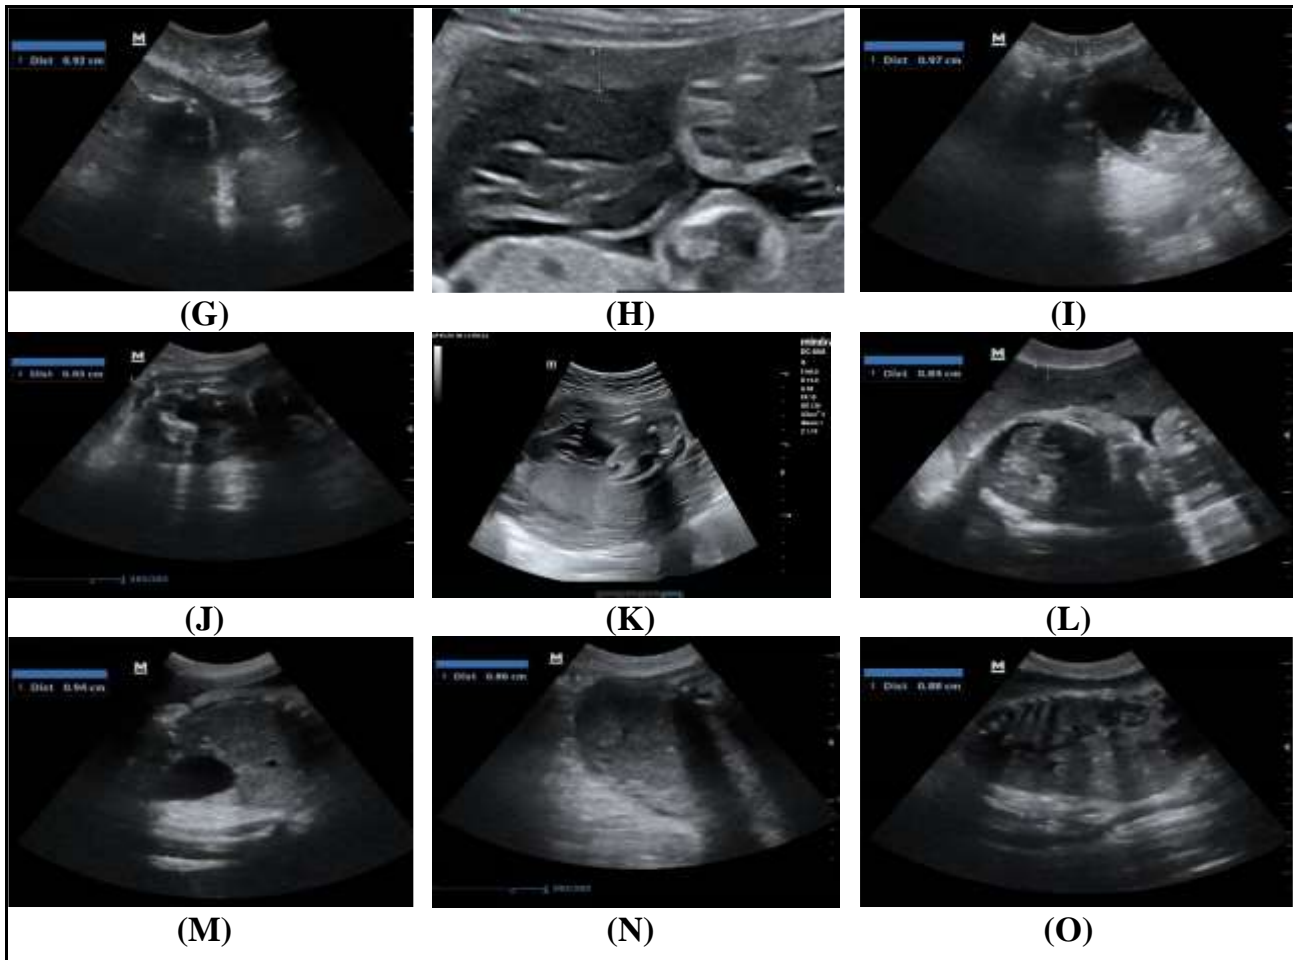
Ultrasound showing the measurement of anterior MT (A) Group A1, (B) Group B1 with gestational age 28 weeks, (G) Group B2, (H) Group A2 with gestational age 30 weeks, (K) Group A3, (L) Group B 3 with gestational age 32 weeks, fundal MT (C) Group B1, (D) Group A1 with gestational age 28 weeks, (I) Group B2, (J) Group A2 with gestational age 30 weeks, (M) Group A3, (N) Group B3 with gestational age 32 weeks, (E) MT at anterior, (F) MT at fundus, (O) posterior MT (Group A3) with gestational age 32 weeks
